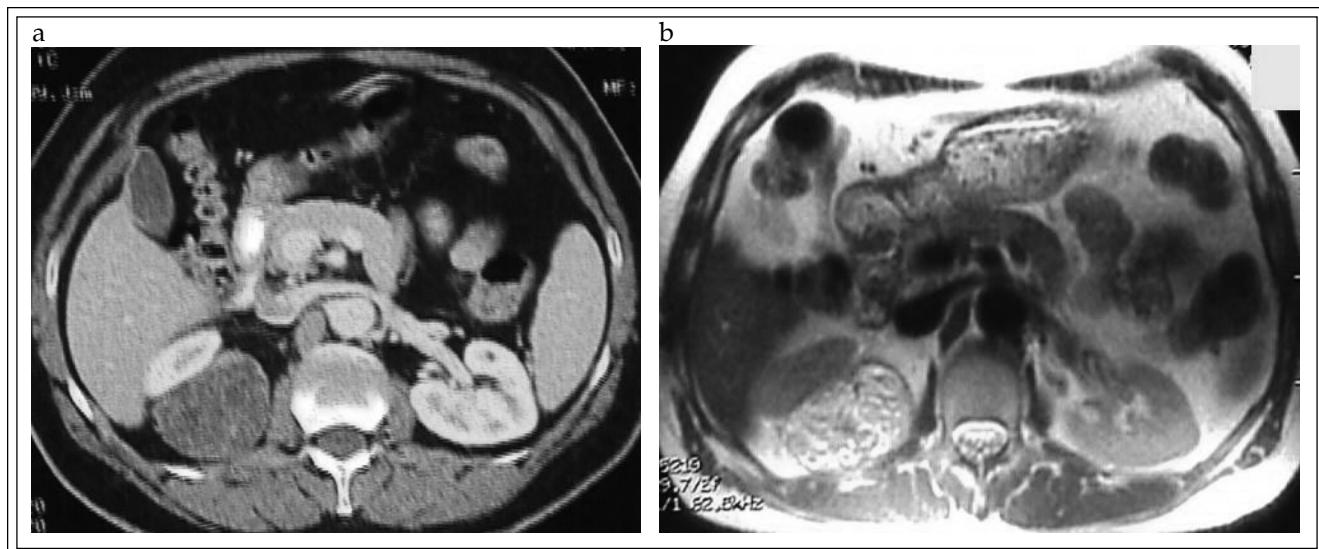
CT demonstrating right perirenal mass (1a). MRI with gadolinium enhancement of the right kidney with mass in transverse T2-weighted section (1b).
